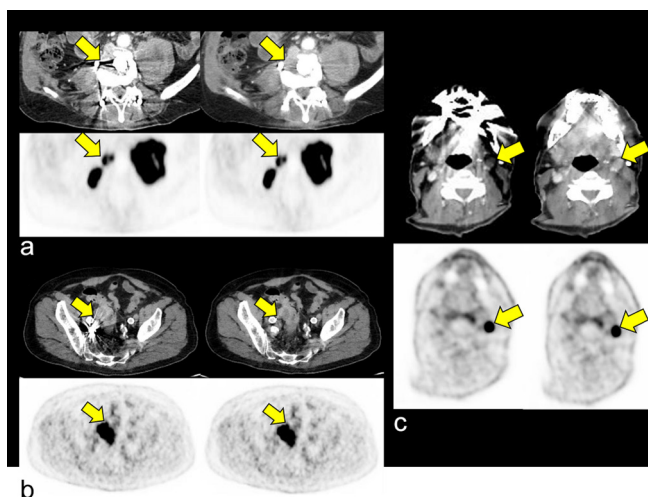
Impact of iMAR on delineation of a retroperitoneal lymph node metastasis in the vicinity of an internal fixator [A, score 1 (noMAR) vs score 2 (iMAR)], a sigmoid carcinoma adjacent to coils in the right A. iliaca interna [B, score 1 (noMAR) vs score 2 (iMAR)] and a lymph node metastasis in neck level III in the vicinity to dental implants [C, score 1 (noMAR) vs score 2 (iMAR)]. The respective lesions are poorly delineable in noMAR CT (upper rows, left columns) while iMAR improves its delineation (upper rows, right columns). No impact of iMAR on PET quantification and qualitative PET evaluation was observed [bottom rows, e.g. dental implants, SUVmean 16.9 (iMAR) vs 16.8 (noMAR)]. CI, confidence interval; HU, Hounsfield unit; iMAR, iterative metal artifact reduction; SUV, standard uptake value.
